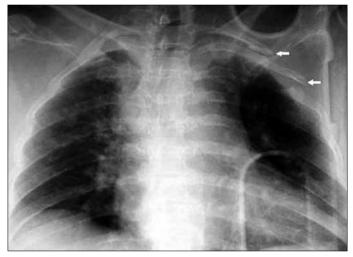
Left first and second rib lateral fractures showing on chest x-ray, (white arrows)
